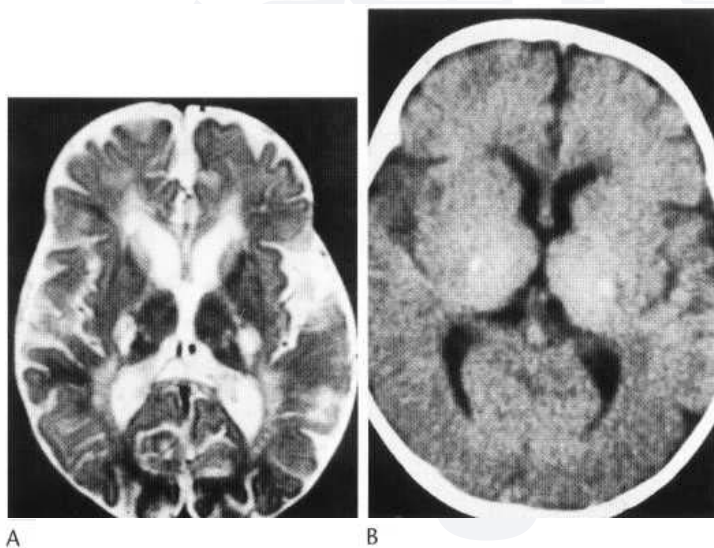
(A,B) Axial CT and T_2 -weighted MRI in Krabbe's disease showing focal bilateral thalamic and posterior internal capsular lesions which are calcified on CT. T_2 signal abnormality is also present in the deep periventricular white matter with some cavitary change adjacent to the frontal horns.
